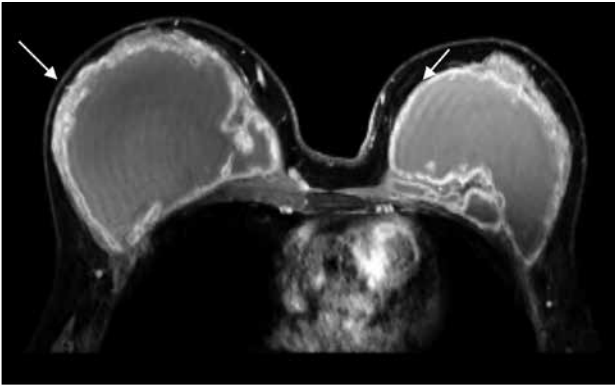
Polyacrylamide hydrogel augmentation complicated by infection. T1-weighted fat-saturated contrast-enhanced axial magnetic resonance imaging demonstrates capsular enhancement (arrows) of both collections, representing infective or inflammatory changes.
